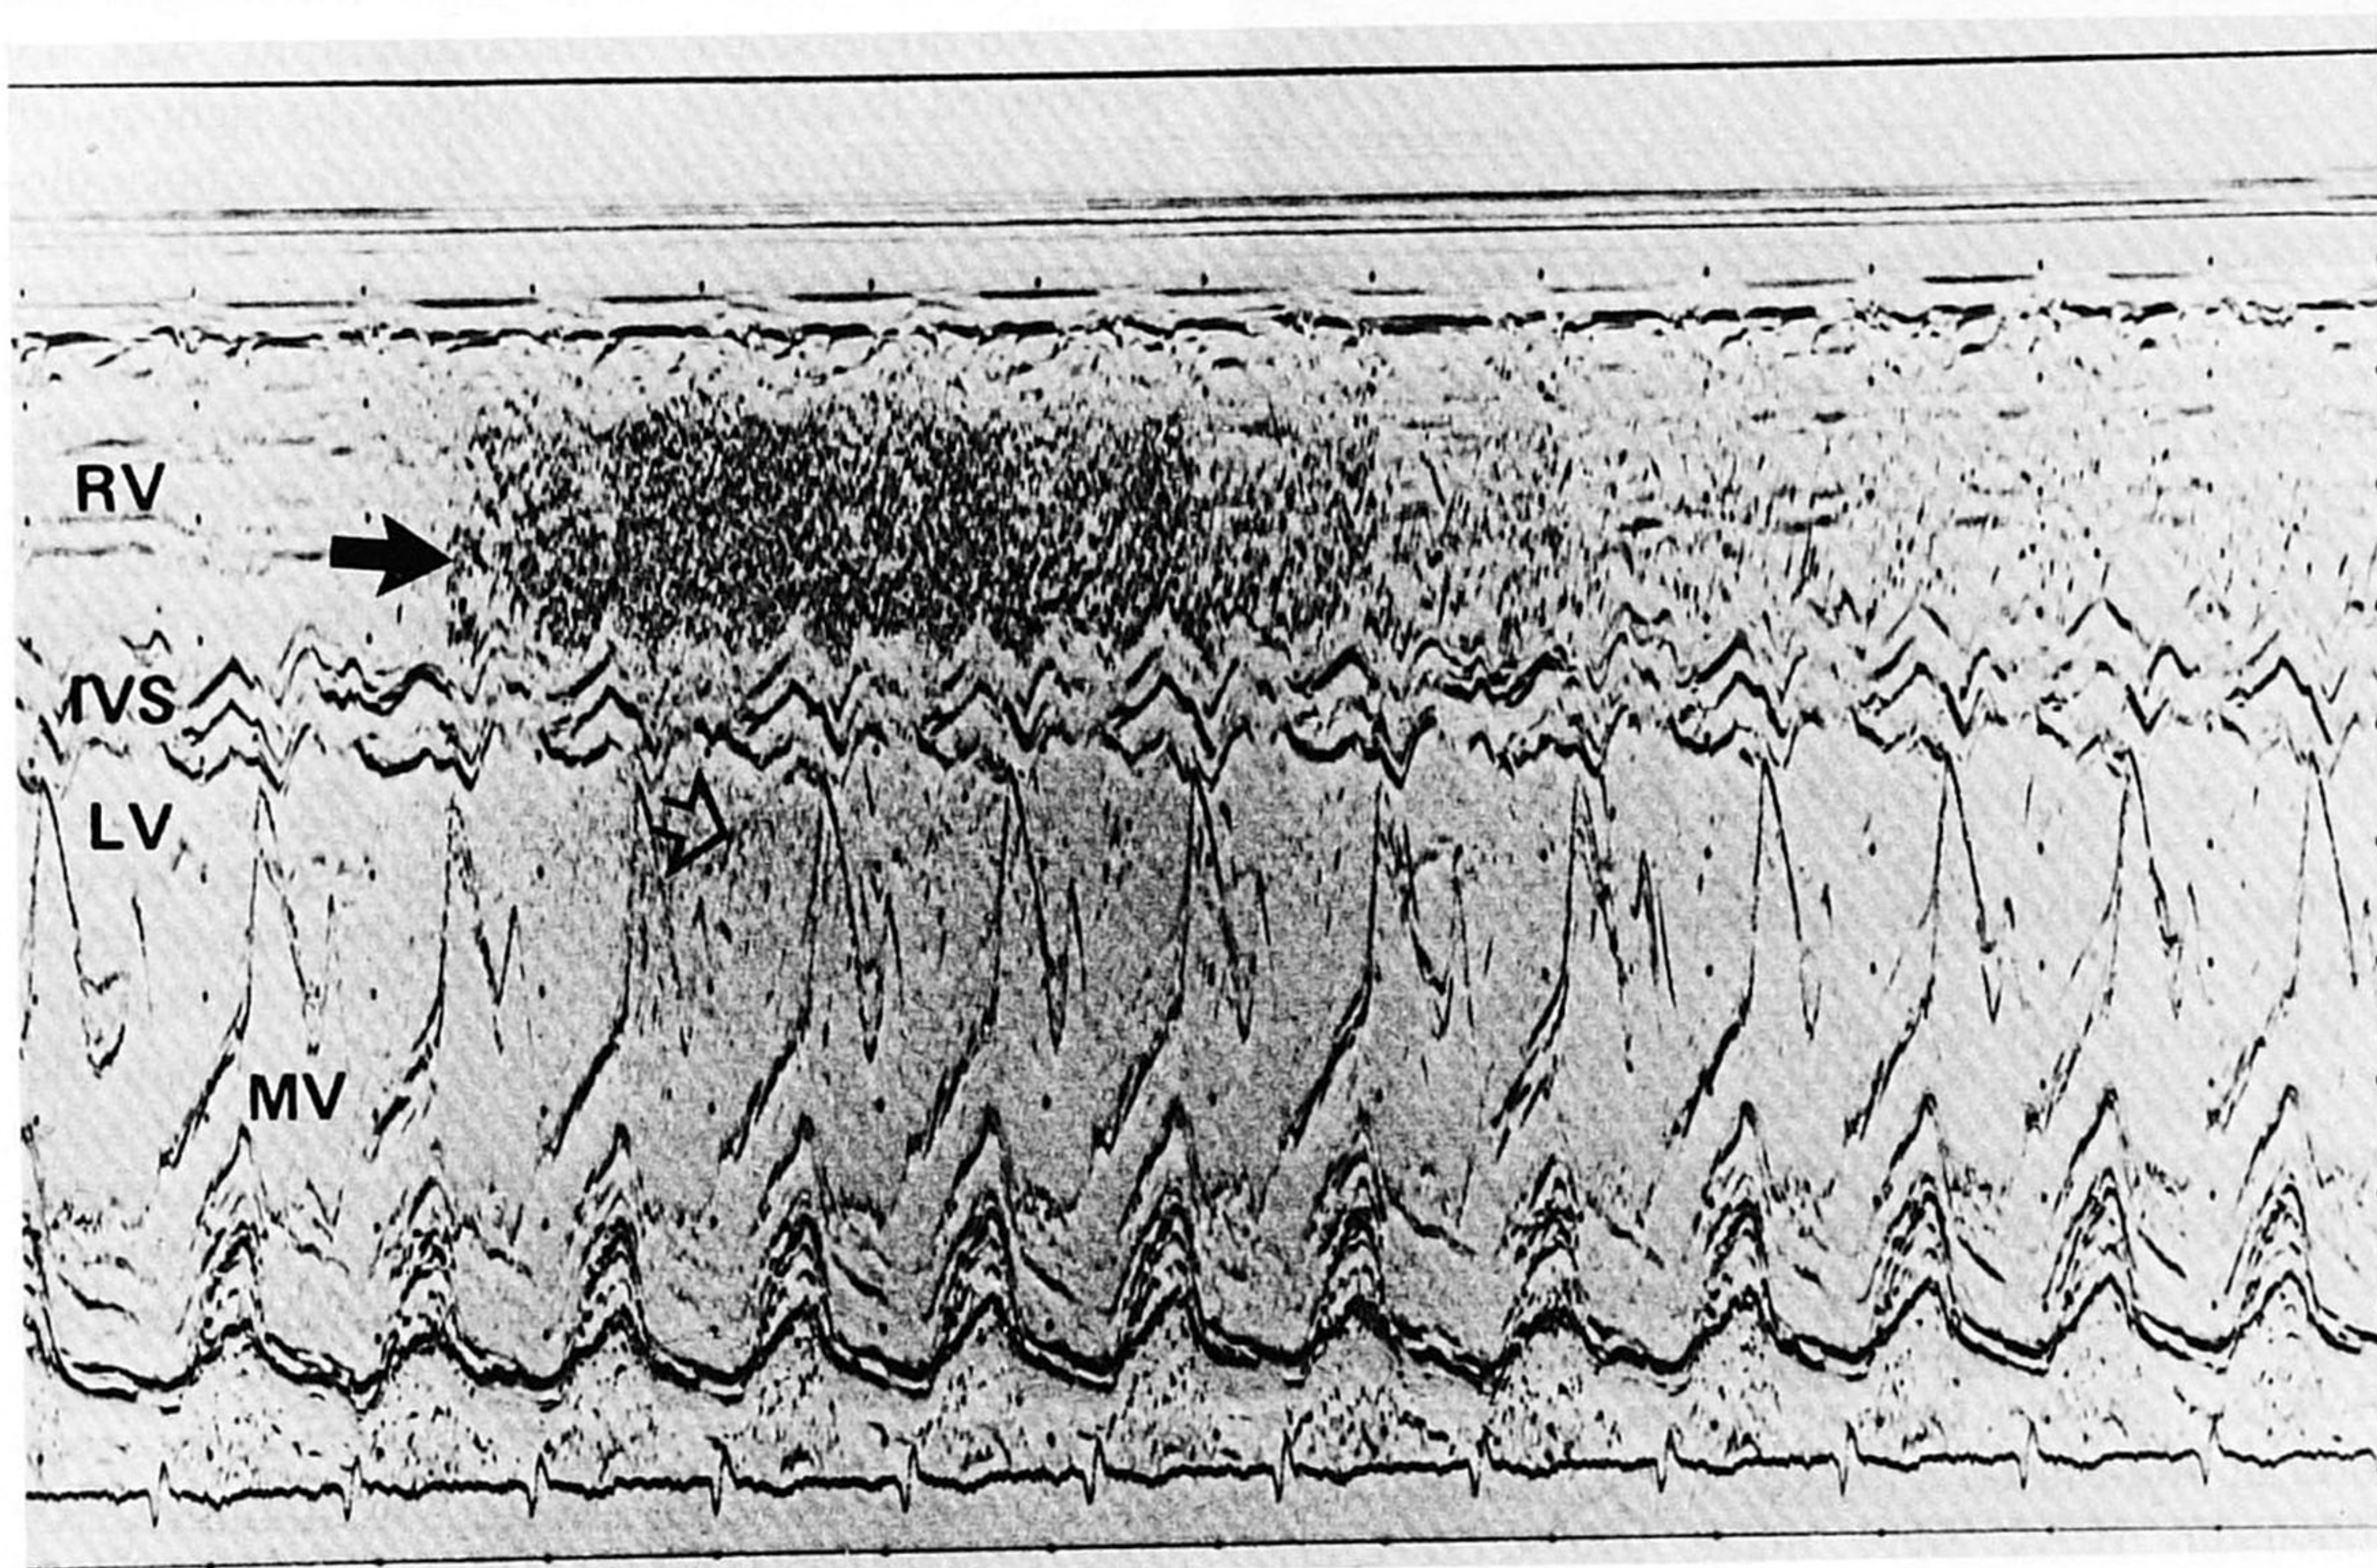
Postoperative M-mode contrast echocardiogram from patient 4 at the mitral valve (MV) level. Peripheral venous injection of 5% dextrose solution performed before the start of this tracing. Note presence of contrast in the right ventricle (RV) (closed arrow) and left ventricle (LV) (open arrow), indicating an intracardiac shunt. IVS = interventricular septum.
